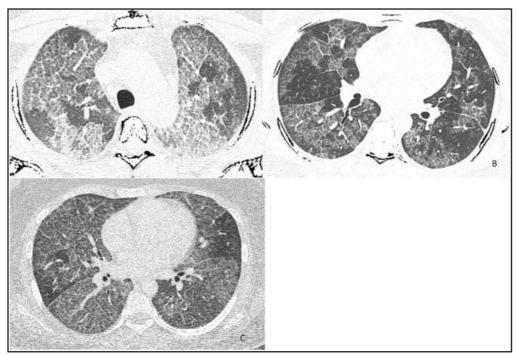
Axial view CT thorax in lung window demonstrating cases of pulmonary alveolar proteinosis. (A) Case 1, (B) Case 2, (C) Case 3 with all scans showing patchy, "geographic" pattern of ground glass opacification superimposed on interlobular septal thickening in multiple lobes.
